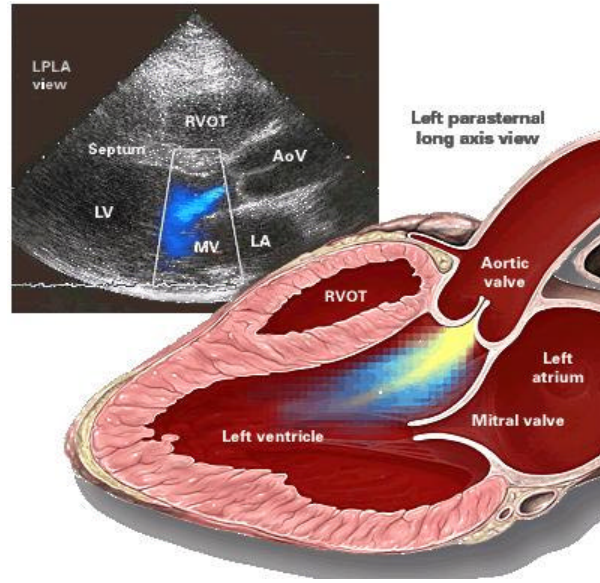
A typical Doppler echocardiograph in a MFS patient. The aortic valve regurgitation is apparent. The graphic shows its nature. Adapted.
